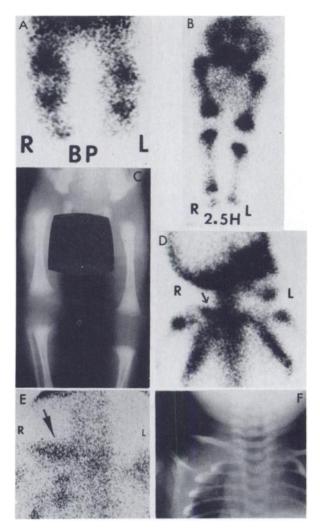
Neonatal osteomyelitis of proximal right femur, proximal and distal right tibia, and proximal left tibia in 7-day-old male. (A) Blood-pool and (B) delayed bone images using converging collimator show slight hyperemia to right knee with mild increased bone uptake in right femur and right proximal and distal tibial metaphyses. Left knee was felt to be equivocal. (C) radiograph of legs shows soft tissue swelling only. Delayed bone scans in 35-day-old male with neonatal osteomyelitis of right clavicle, using (D) high-resolution collimator and (E) pinhole collimator show increased radioactivity in right clavicle (arrows) with diffuse soft tissue increase. (F) Radiograph shows no bony abnormality.
